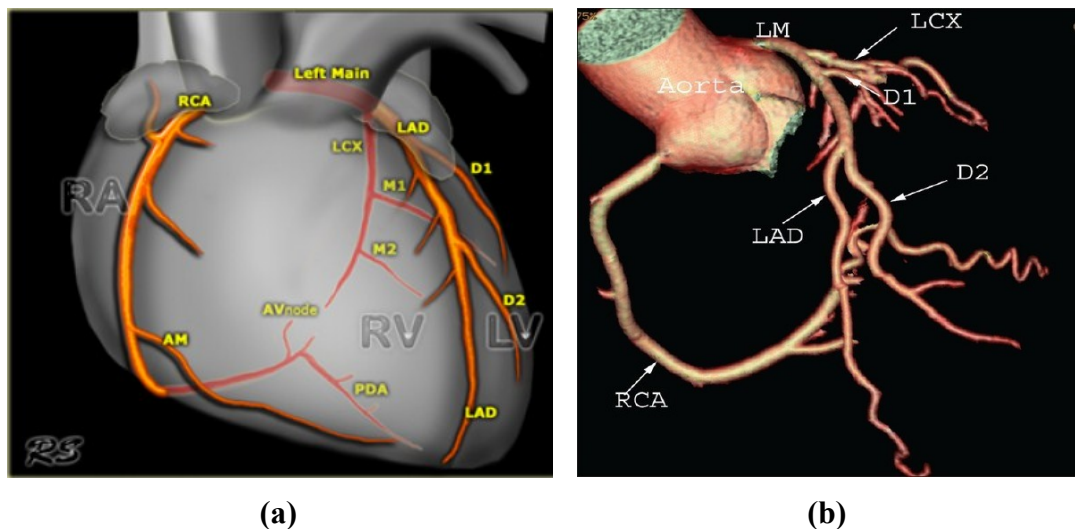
Coronary vessel anatomy in the anterior projection on the left [14] and 3D volume rendered from CT angiogram on the right [15].
